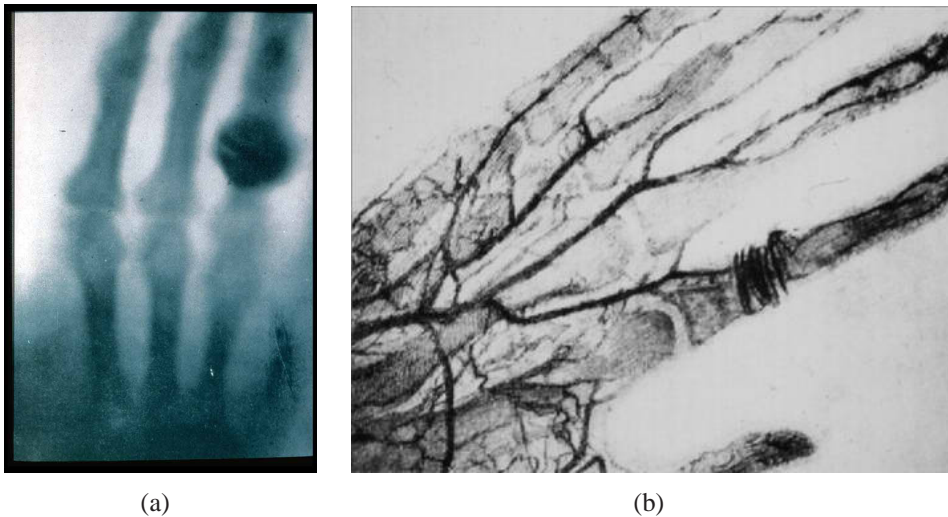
(a) The first X-rays image obtained by Röntgen in December 1895 and (b) the first angiogram image obtained by Mr. Haschek and Dr. Lindenthal in January 1896.
